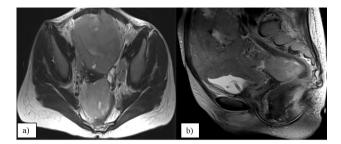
MRI: a) axial image showing infiltrative urinary bladder lesion and tumor mass in the presacral region, as well as bilateral enlargement of the parailiac lymph nodes; b) sagittal image showing diffuse intestinal infiltration; catheter is placed into the bladder.
